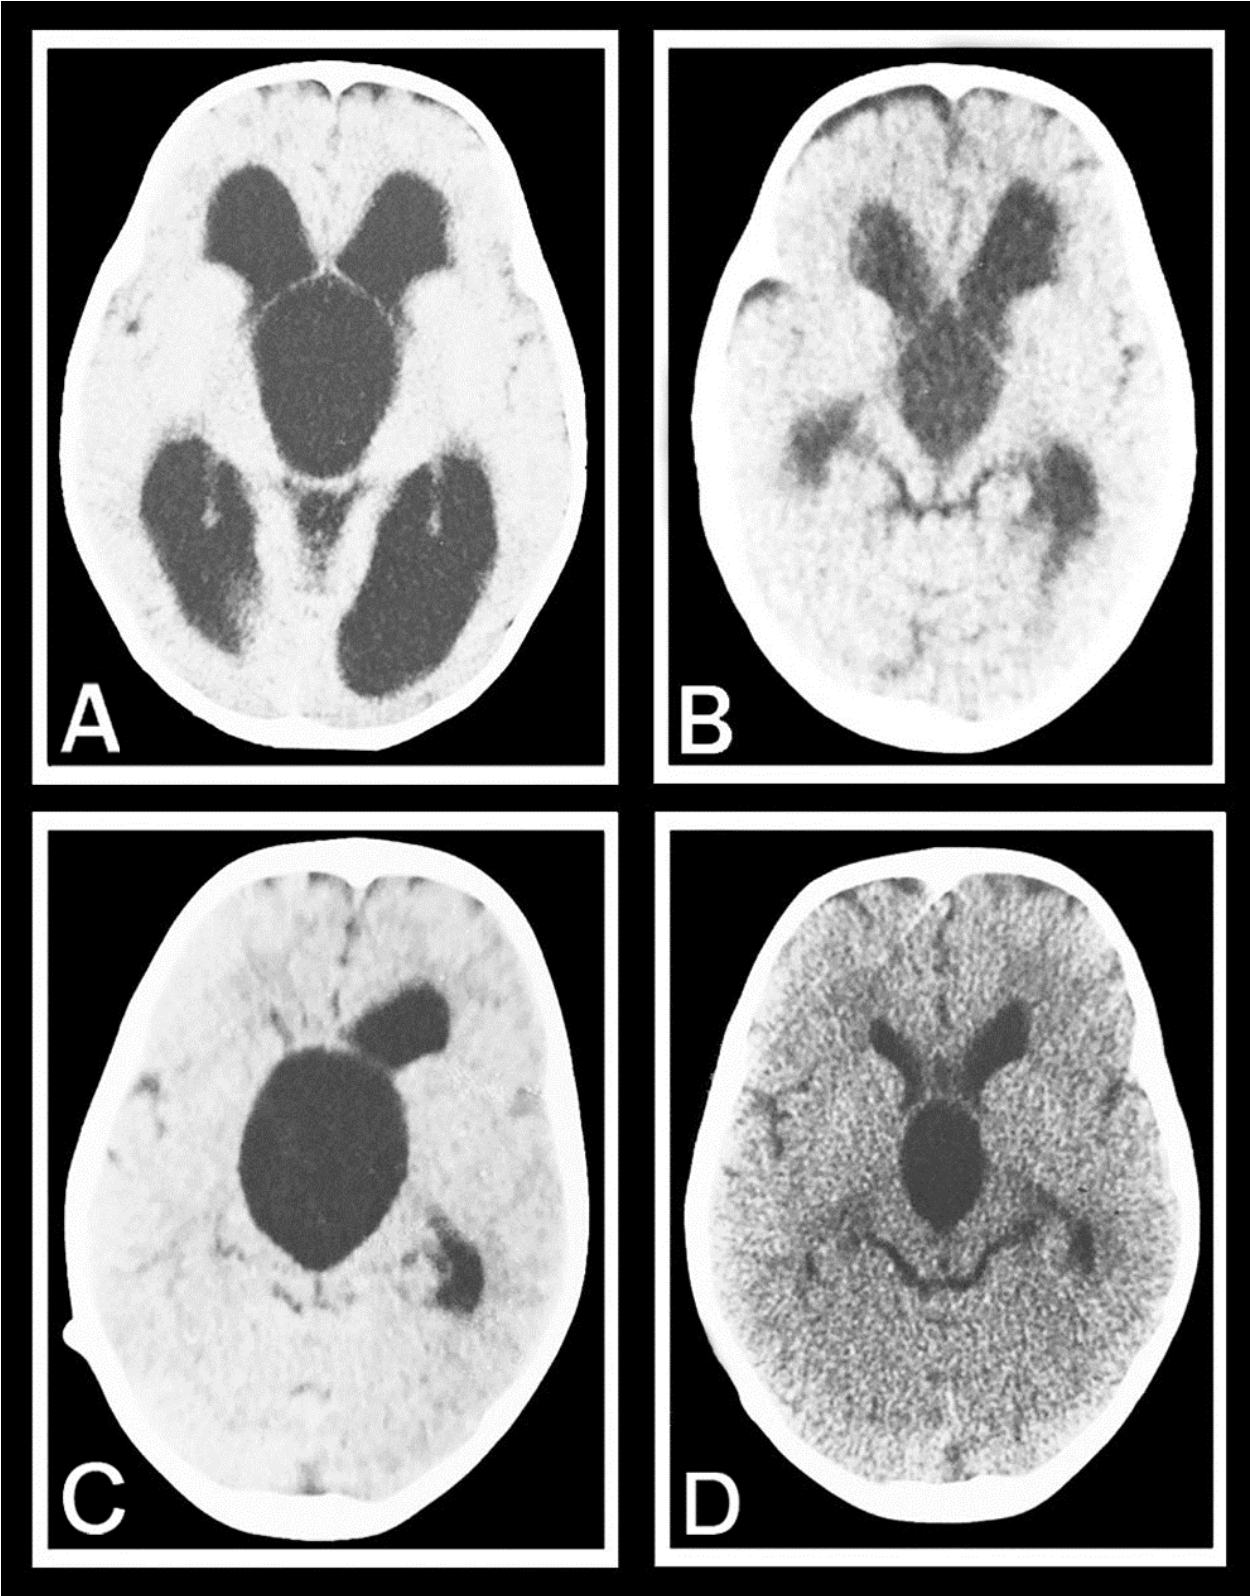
A: Axial T1 weighted MR imaging showing a huge suprasellar arachnoid cyst with marked obstructive hydrocephalic changes. B: Axial CT scan performed 3 months after endoscopic ventriculocystocisternostomy showing apparent decrease in size of both the cyst and hydrocephalus with opening of the subarachnoid space. C: Axial CT scan showing
